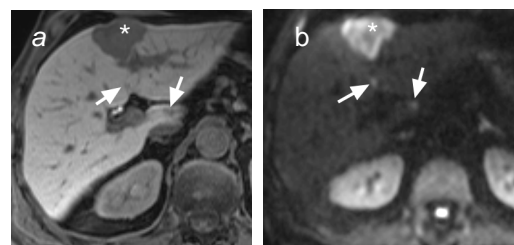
(a) T1W post Gd-EOB-DTPA and (b) b = 750 s/mm<sup>2</sup> DW-MRI images showing a large metastasis (\*) in left lobe of liver. Note two < 1 cm metastases (arrows) visible on DW-MRI but overlooked on contrast enhanced image.
